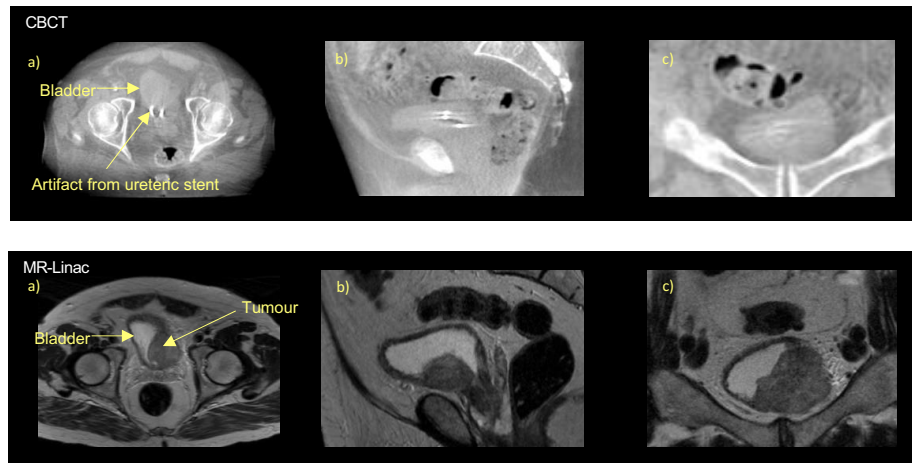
Online pre-treatment CBCT and MR (T2W) images. Bladder tumour at left bladder wall as seen on axial a), sagittal b), and coronal c) views of the pelvis on corresponding CBCT and T2W taken on the MR-Linac, here urine appears bright and tumour dark/hypointense.
